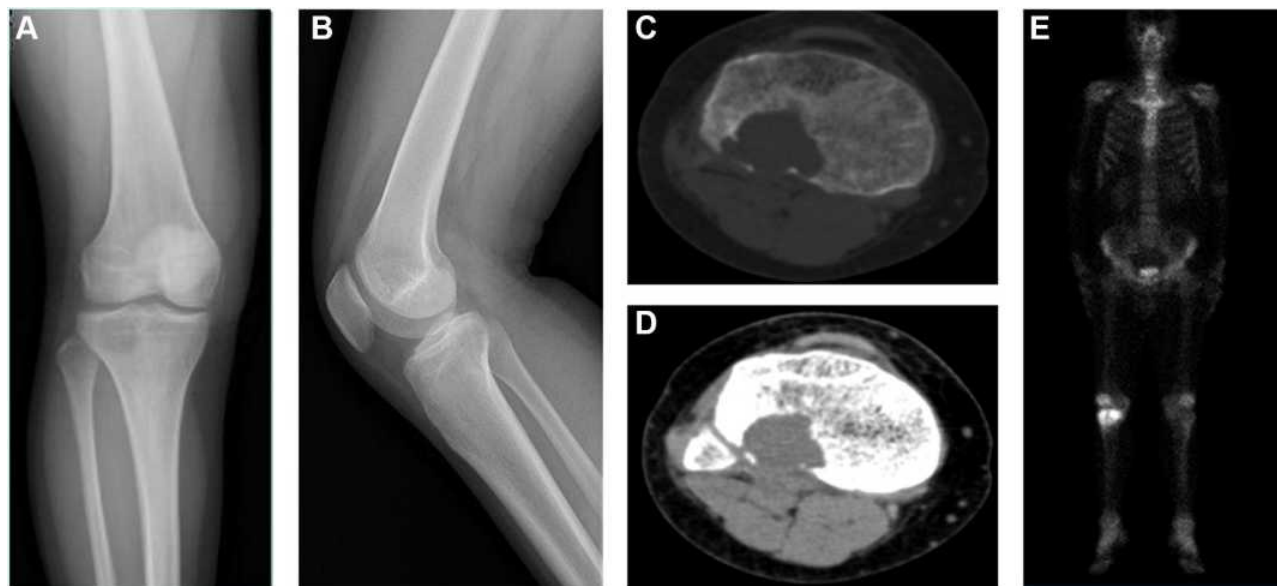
Radiological images of the proximal right tibia. Radiograph (A and B) and CT (C and D) showed osteolytic bony destruction. SPECT (E) images were negative for metastatic lesions.
